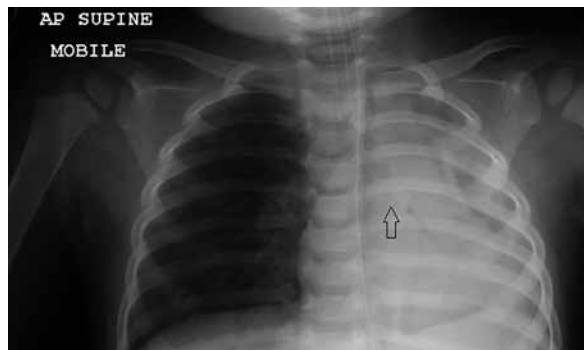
A repeated chest radiograph shows that the foreign body migrated into the left main bronchus and left lung collapse
